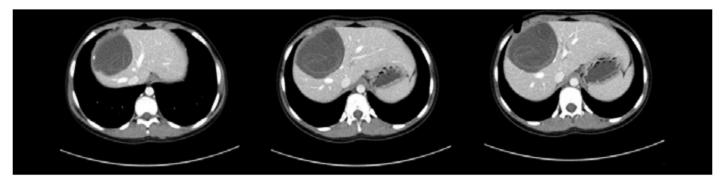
a-c. In the contrasted abdominal CT of the patient; a cystic lesion with a small calcification on its wall and a germinative membrane with a fluctuating course detached from cyst wall within this cystic lesion are visible in the right lob antero-superior segment of the liver (segment 8). This tomographic image is compatible with the phase CE3 in the USG-based classification of the WHO. (By the written permission from the archive of the Pediatric Thorax Council of the Department of Pediatric Infectious diseases of the Uludağ University Medical Faculty).
